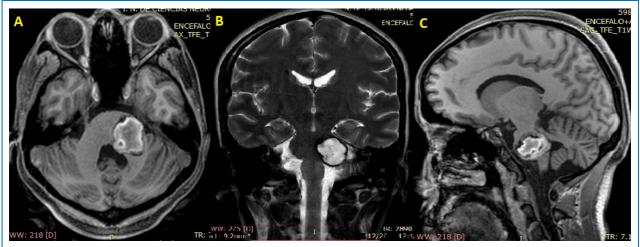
Brain MRI without contrast, 5 months before admission, showing a bulging hemorrhage in (A) axial view T1, (B) coronal view T2, (C) sagittal view T1.
